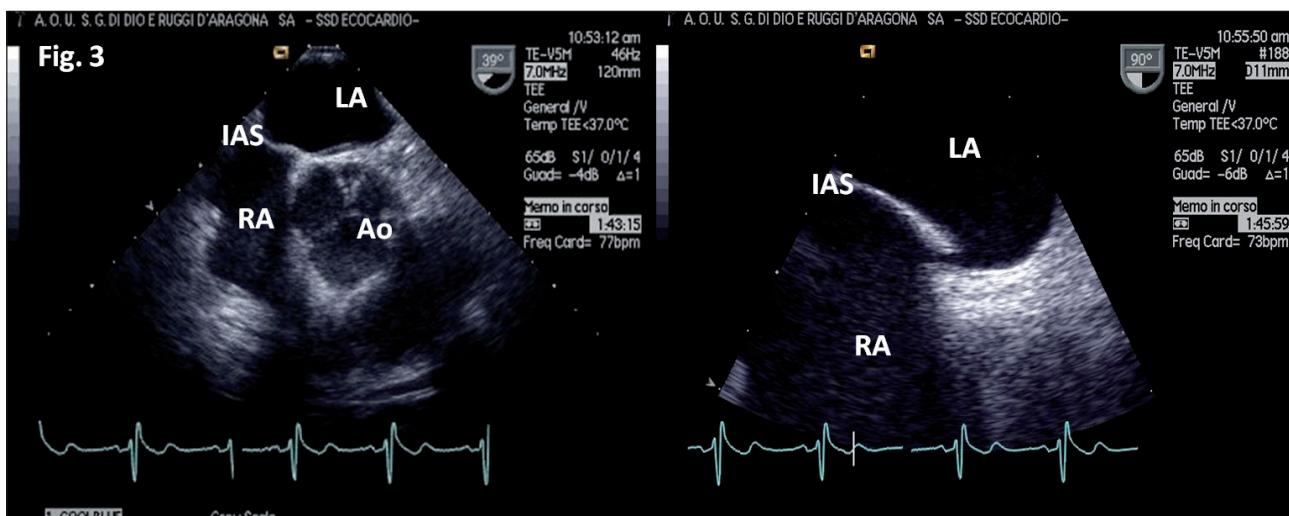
A third transesophageal echocardiography revealed no thrombus after anticoagulation therapy. LA, left atrium; RA, right atrium; IAS, interatrial septum; Ao, aorta.
